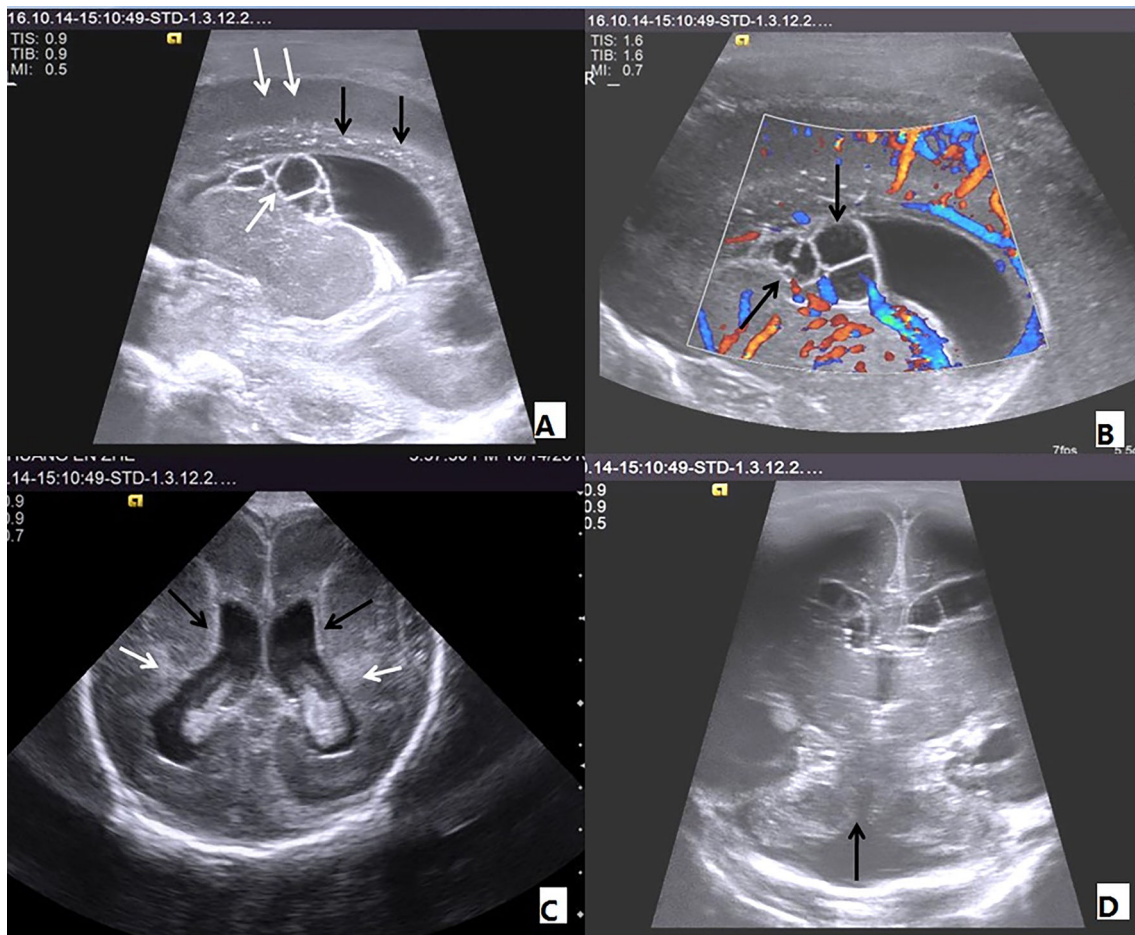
Cranial ultrasound of a 25-day-old male baby with lissencephaly. a Abnormal periventricular cysts located within the germinal matrix and abnormal smooth appearance of the brain with a lack of sulcation (white arrow), consistent with a disorder of neuronal migration such as lissencephaly and diffuse calcifications around the ventricles of the brain (black arrow). b Color Doppler flow imaging
